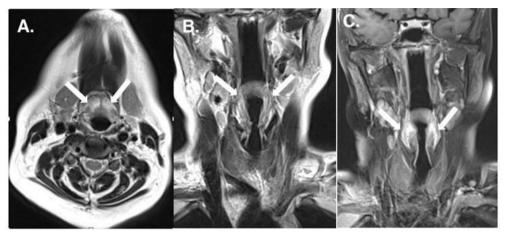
(A): Axial and (B) T2-weighted images show diffuse mucosal thickening at the pharyngeal surface of the aryepiglottic folds and at the base of the lingual surface of the epiglottis (white arrows). (C) Post-gadolinium T1 image shows enhancement in the mucosal thickening in the superior hypopharynx (white arrows). The appearance is suggestive of inflammatory mucosal thickening, such as mucositis/epiglottitis.
